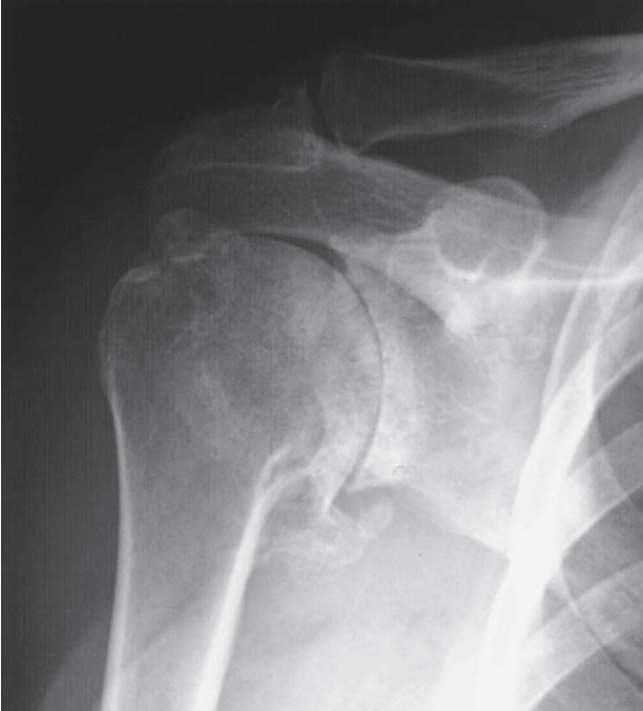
All the classic findings of osteoarthritis are present in this true AP X-ray of the glenohumeral joint, including joint space narrowing, subchondral sclerosis, osteophyte formation, and subchondral cyst formation.
